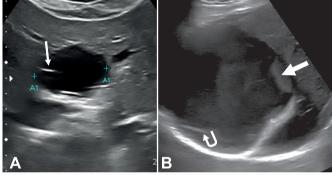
Complex cyst on ultrasound. A) Anechoic cyst with thin septum (arrow). B) Large cyst in the right liver with a thick septum (curved arrow), echogenic content (asterisk) and mural nodule (arrow).
